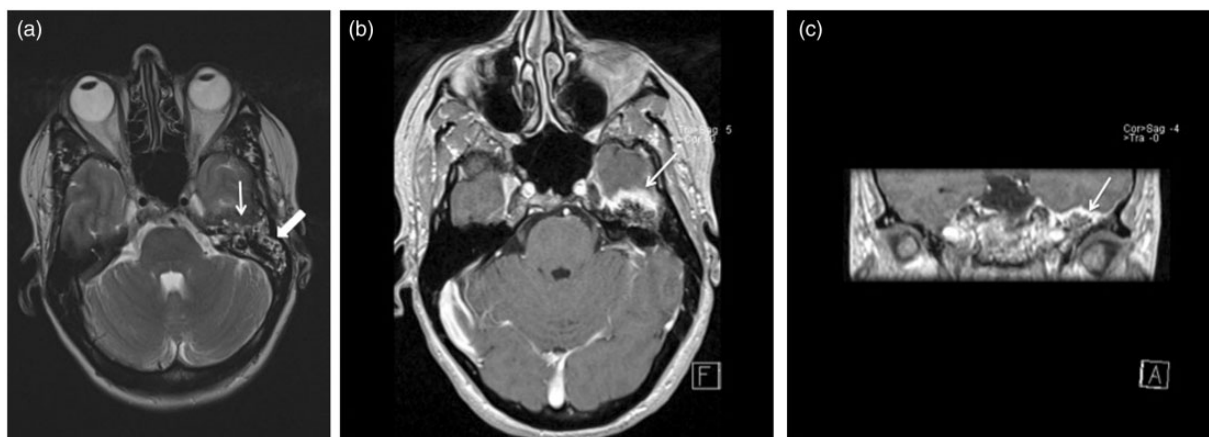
(a) Axial T2W MR image of the brain at the level of the temporal bone pyramid shows a hyperintense signal in the tympanic cavity and partially in the mastoid cells, compatible with serous otitis media (large arrow). Note the hypointense and thickened aspect of the anterior wall of the left middle ear cavity (small arrow). (b) Axial gadolinium-enhanced T1W MR image at the level of the temporal bone pyramid shows an intensely enhancing anterior wall of the middle ear cavity (arrow). (c) Coronal gadolinium-enhanced T1W image through the temporal bone demonstrates a clear enhancement of the roof of the tegmen. Compare to the normal non-enhancing anterior wall and tegmen on the right side.
